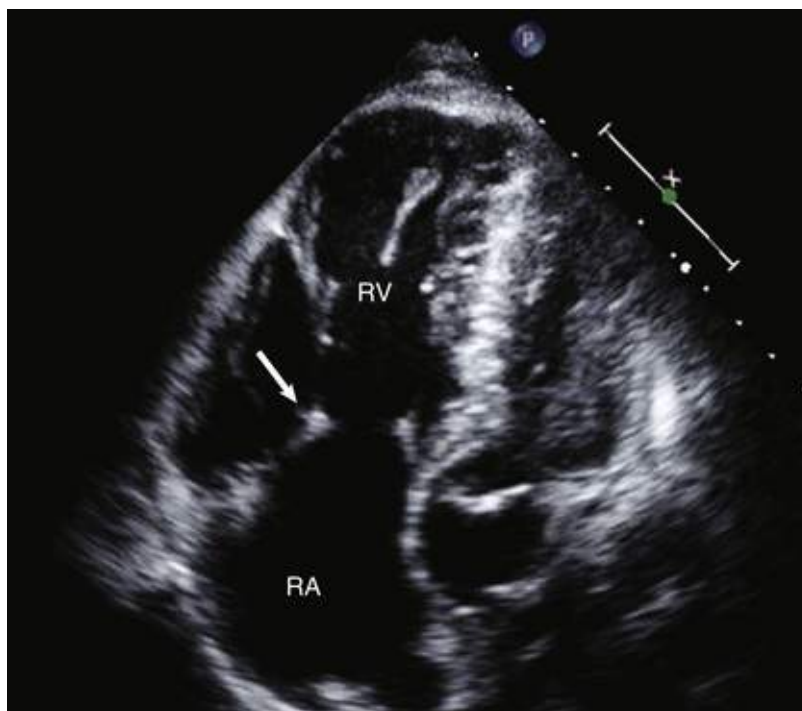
Apical four-chamber view showing the drumstick appearance of the tricuspid valve (arrow), which is characteristic of carcinoid valvopathy. RA, Right atrium; RV, right ventricle.
